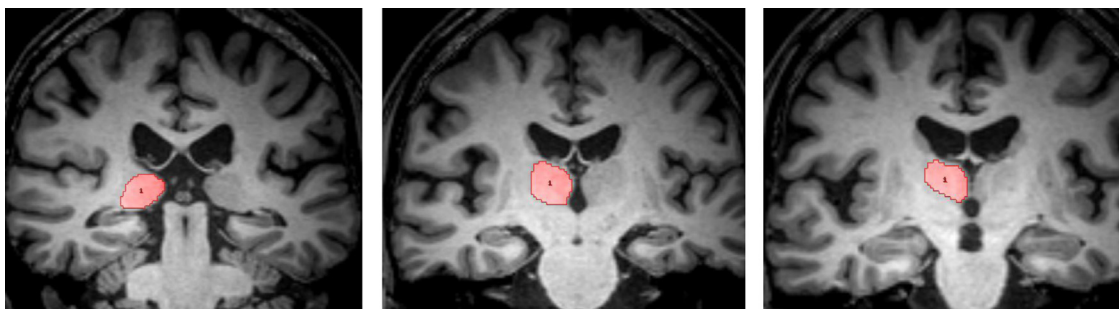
Thalamic morphology in 3 slices in caudal-rostral progression on MRI scans (from left to right).
